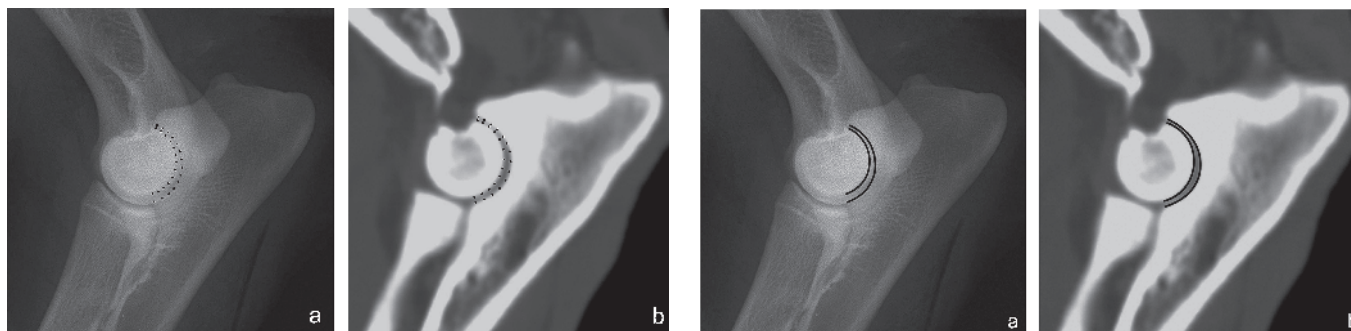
a) Mediolateral radiographic view with $\sim 132^\circ$ of extension, and b) sagittal computed reconstructed elbow tomographic image. A set of 13 or 14 points was marked at the central ridge of the ulnar trochlear notch, from the anconeal process to the base of the medial coronoid process, and on the adjacent humeral trochlear groove, respectively.
